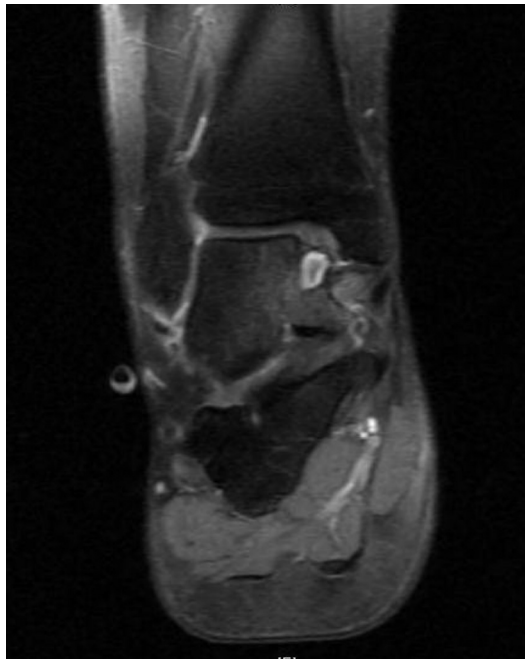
MRI findings of osteochondral lesion with cystic changes and articular damage.
